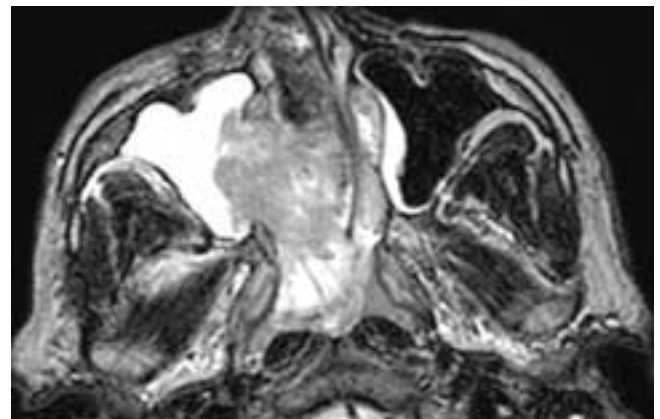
Axial T2-weighted MR image shows a large right-sided nasal fossa mass that has destroyed most of the medial wall of the right maxillary sinus and extends back into the nasopharynx. The mass has areas of high signal intensity that represent sites of necrosis. The right maxillary sinus is obstructed, and inflammatory mucosal thickening is seen in the left antrum. This patient had a squamous cell carcinoma and obstructed secretions.
